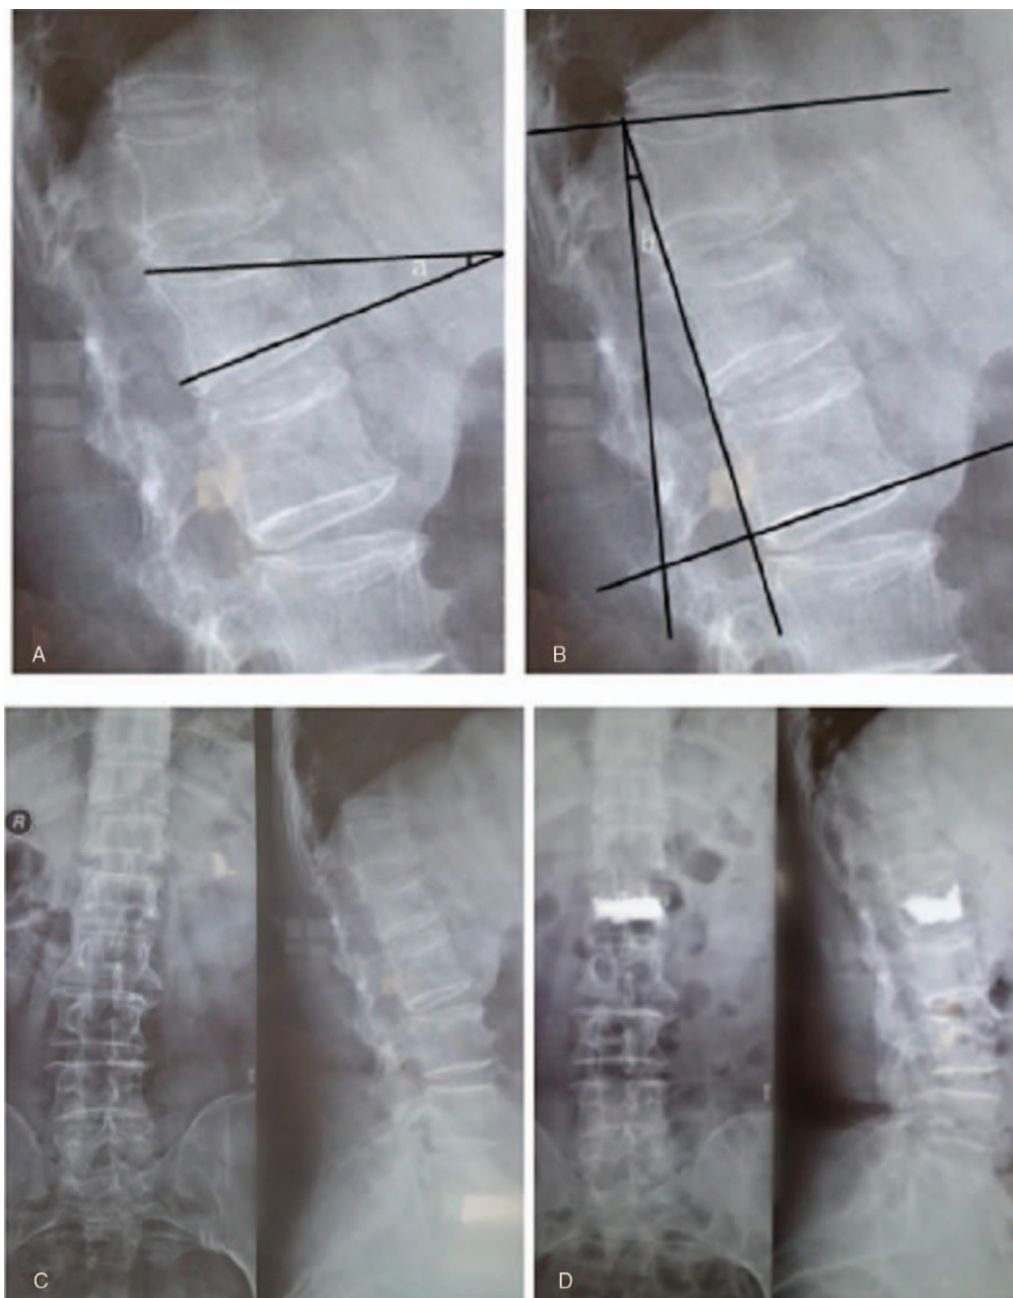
(A) Kyphotic angle; (B) the Cobb angle; (C) the preoperative x-ray slice shows the old OVCF of the lumbar 1 vertebral body; (D) the postoperative x-ray slice shows the lumbar 1 vertebral body is filled with the bone cement.
